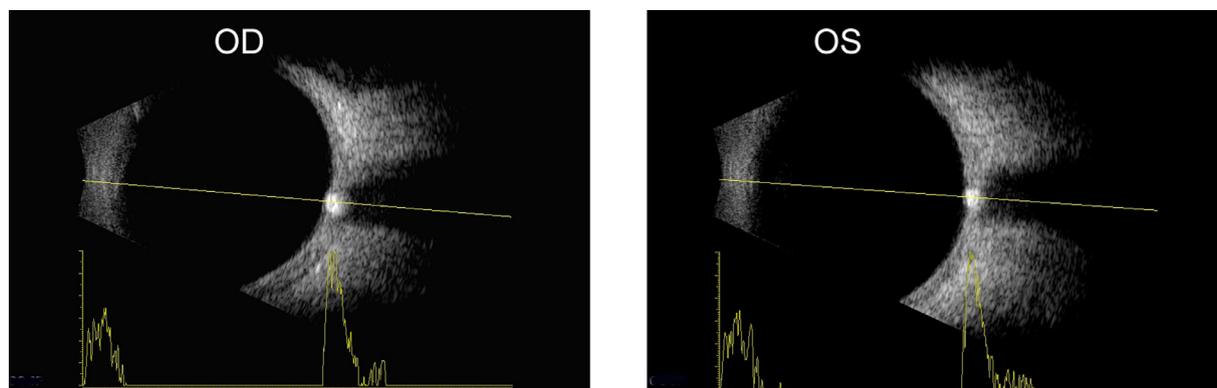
Ultrasonography of the left and right orbits shows calcified optic disk drusen bilaterally.
